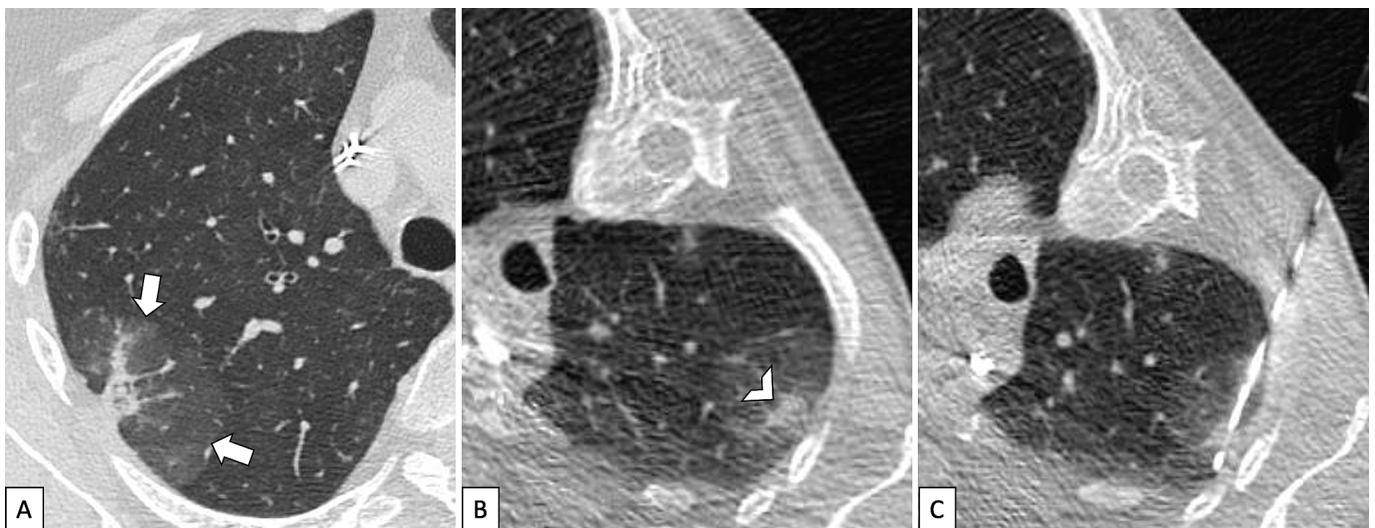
A-C. CT-guided transthoracic core needle biopsy of a part-solid nodule located in the right upper lobe (arrows). B, C. The patient was positioned with the biopsy-side down, targeting the solid component (arrowhead). The final diagnosis was lung adenocarcinoma with lepidic growth.
